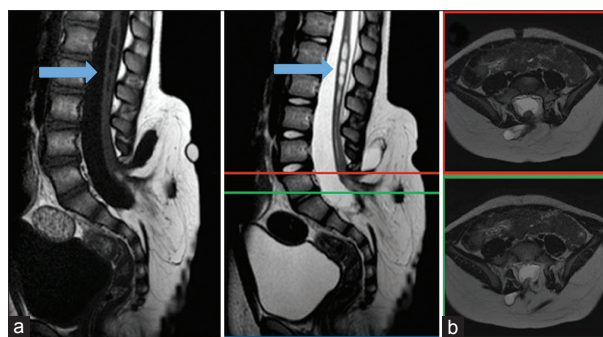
(a) T1 (left) and T2 (right) sagittal sections of an MRI showing the presence of a caudal lipomyelomeningocele with an associated lumbar syrinx (arrows) in a clinically asymptomatic patient. (b) Selected T2 axial sections as identified by the color coding on the sagittal image in A
